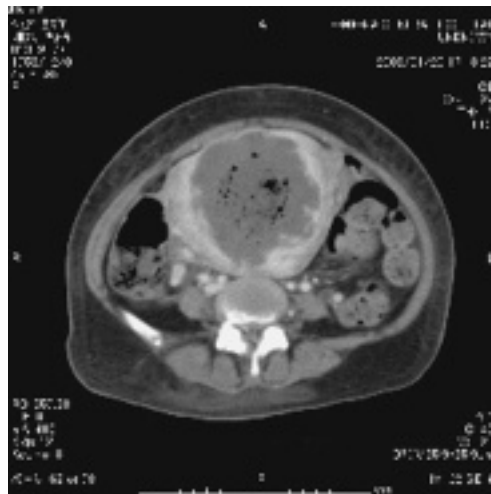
Pelvic computed tomography shows swollen uterus with internal low density area and air.
